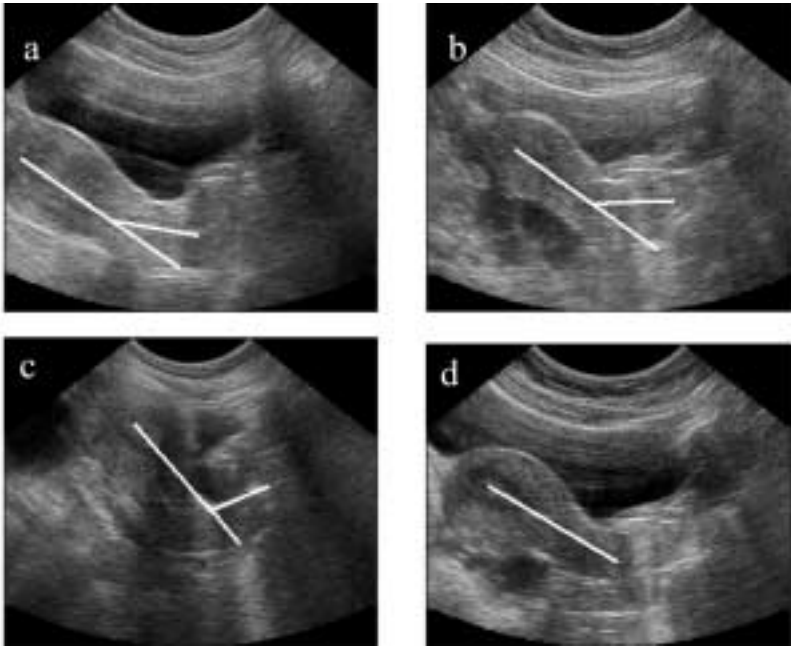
Measuring the utero-cervical angle on abdominal ultrasonography:
